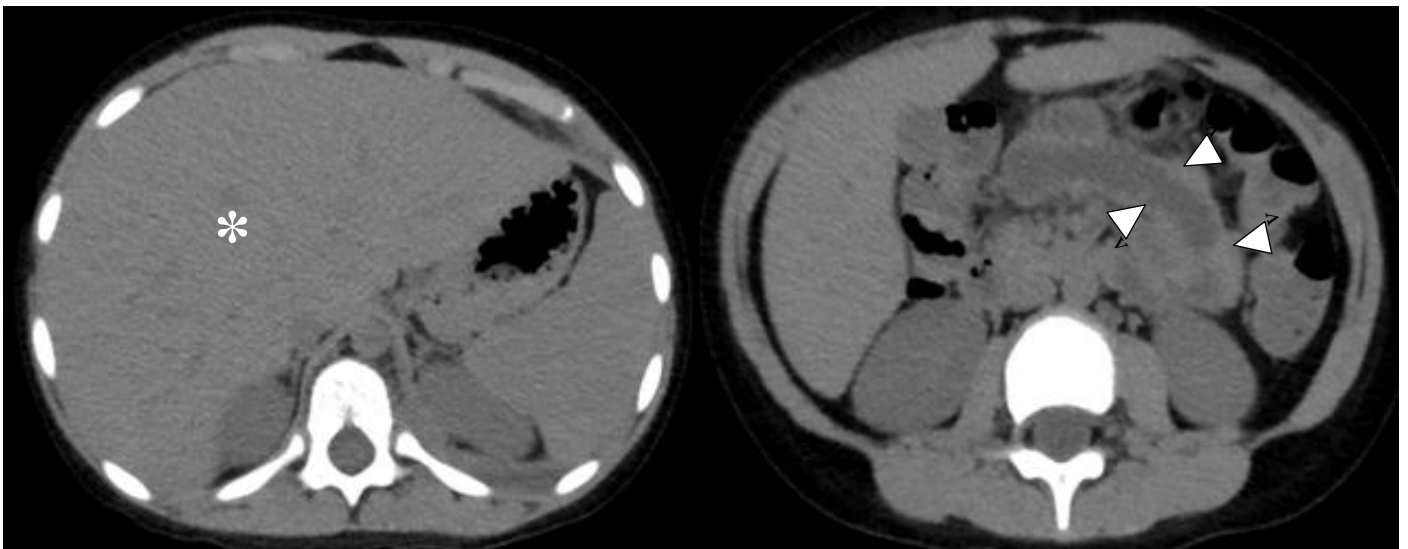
Axial CT scan of an 8-year old boy with dengue infection showing hepatomegaly (A, asterisk) and focal jejunal wall thickening (B, arrowheads).
